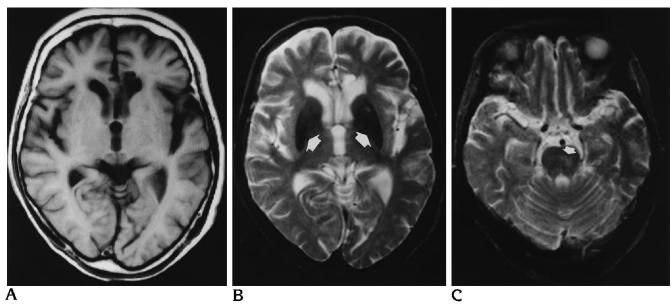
MR images, 11 months after onset. A, T1-weighted MR image (500/15/2). The hyperintense putamen becomes normal in intensity. B, T2-weighted MR image (2500/90/1). The signal intensity remains low in the putamina (arrows). C, T2-weighted MR image (2500/90/1). The pontine lesion is reduced in size (arrow).
